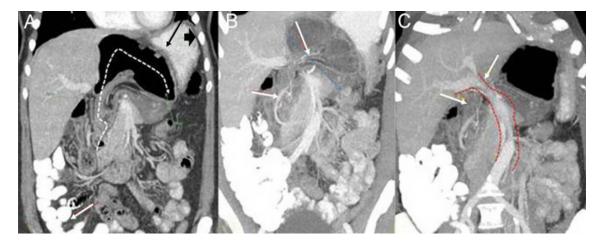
Contrast-enhanced computed tomography. Coronal plane. A. The colonic content of the internal hernia is seen, with the cecum (black arrow) displacing the gastric fundus (black arrowhead) and the absence of the right colon in the abdomen (white arrow). B. Ileocolic artery with an abnormal course running cephalad to the lesser sac, accompanying the cecum. C. The passage of the hernial contents deforms the hepatoduodenal ligament through which the hepatic artery, portal vein, and biliary tree run (arrows).
